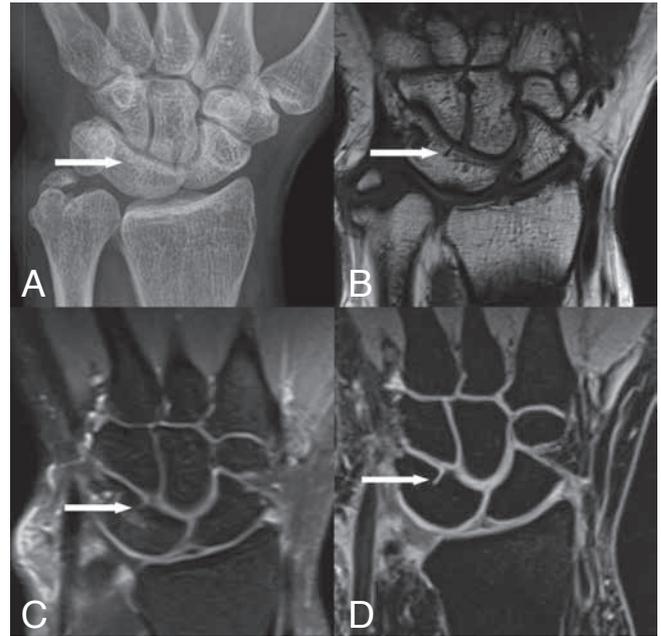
Reevaluation on MRI compared to plain radiography (patient 2). A. Plain radiography, B: Coronal SE T1-WI, C: Coronal SE T2-WI and D: coronal 3D-GRE. A. Based on plain film evaluation LTC seems complete, in compliance with Minnaar type 3. B, C and D: on MRI of the same patient, a (small) distal notch can be seen, thus redefining this case as type 2 Minnaar.
